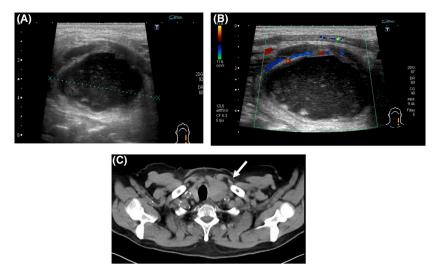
(A, B) Well-circumscribed large cystic mass with debris in left thyroid gland in neck at ultrasonography. (C) An abscess in the left lobe of thyroid gland in neck CT (arrow).
